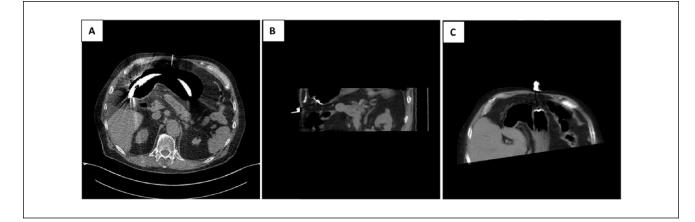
Seventy-eight-year-old patient with esophageal cancer was referred for feeding percutaneous gastrostomy prior to scheduled radiochemotherapy. No adequate transillumination could be obtained during previous esophagogastroduodenoscopy. (A) Gastroscope is shown inside the stomach (computed tomography–guided puncture of the stomach). (B–C) Images after placement of the tube (pull-through type) inside the stomach.
